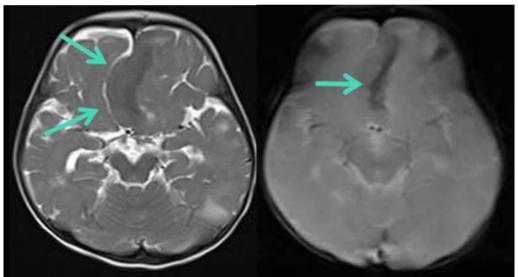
MRI Brain axial A (T2WI) and B (GRE)
